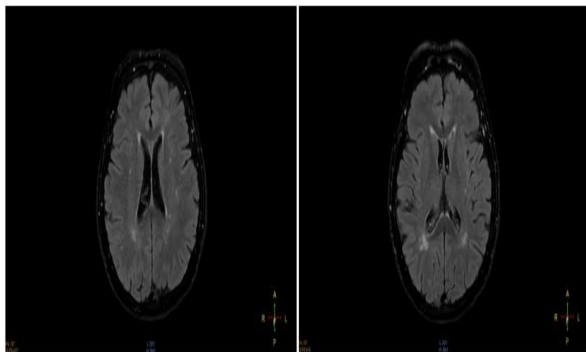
MRI showing multifocal lesions of the periventricular white matter.
